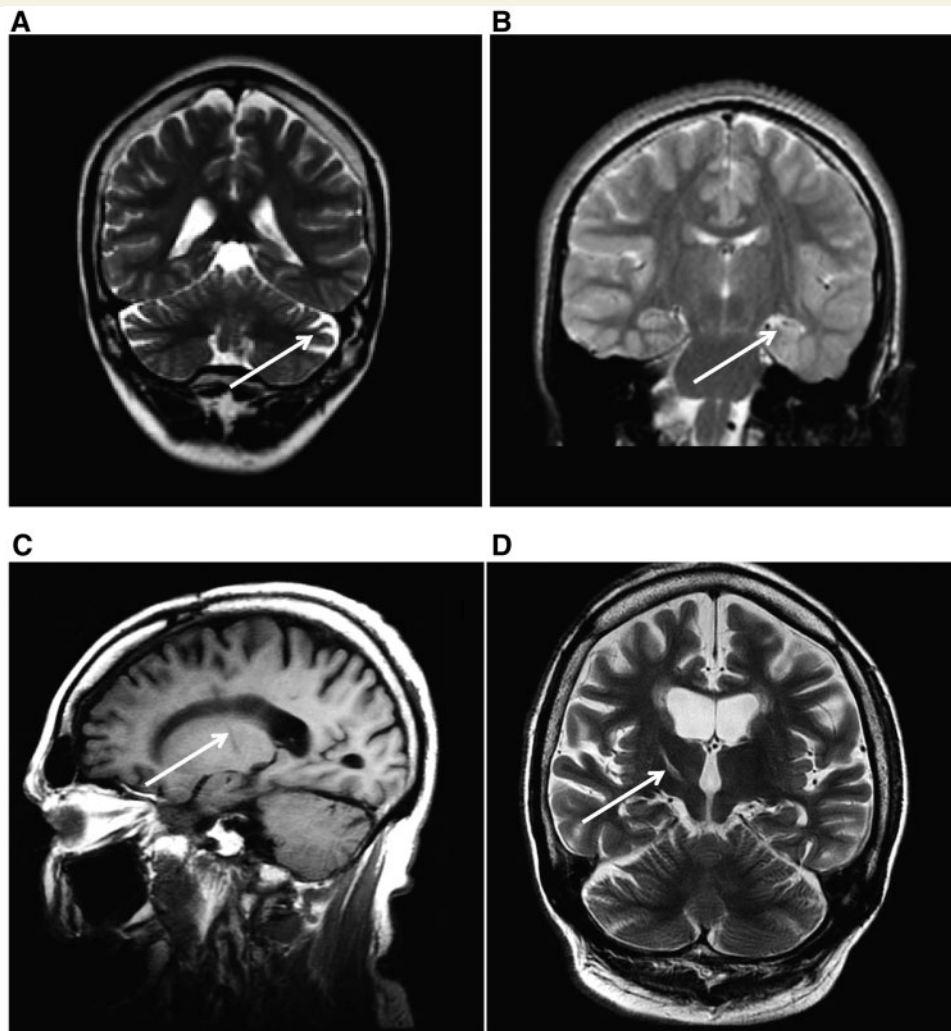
Brain MRI findings in adults with Dravet syndrome and *SCN1A* mutation. Cerebellar atrophy (A, sagittal T₁, Case 6) was a feature in some cases. Case 21 was the only adult case with Dravet syndrome in our series with hippocampal sclerosis (left in this case) evident on MRI (B, coronal T₂). Case 6 had a stereotactic thalamotomy at the age of 16 years (C, sagittal T₁ and D, coronal T₂). Arrows show the location of the main abnormalities in each image.
